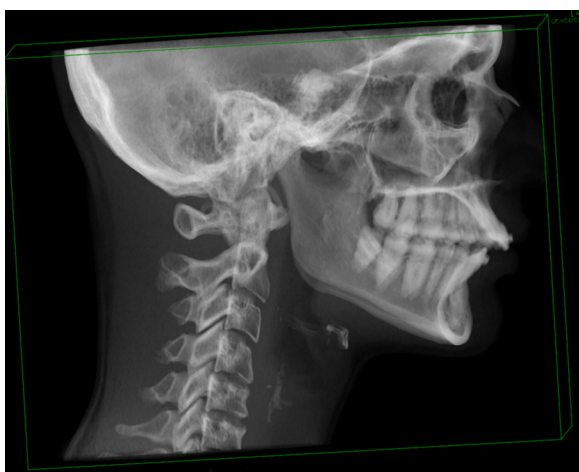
Example of CT-generated lateral cephalogram. For superimposition of the left and right sides, skull base outlines were preferred to mandibular outlines.
